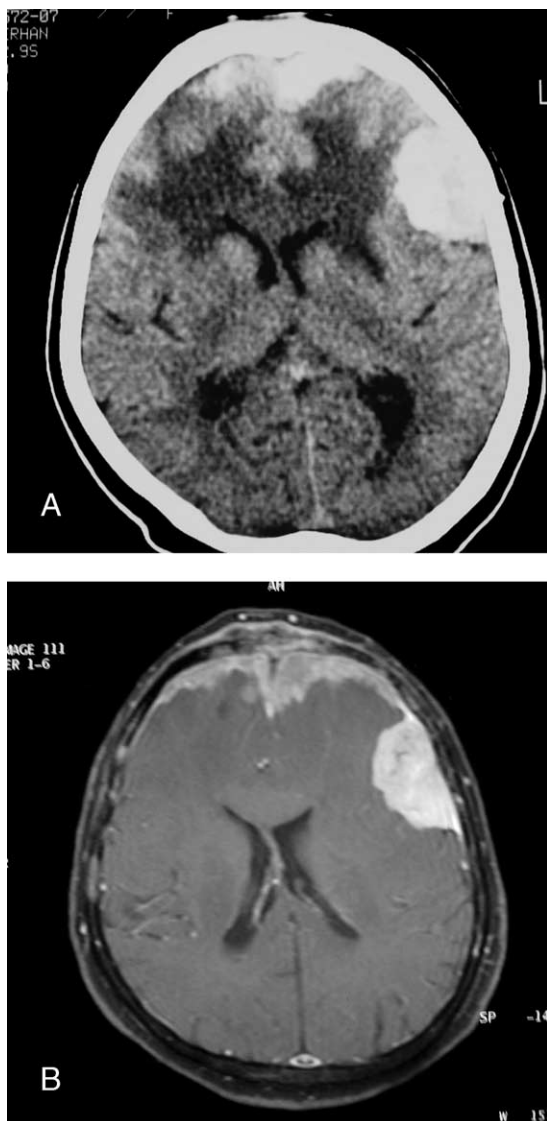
A: Contrast-enhanced CT image demonstrating bilateral frontal mass and left sylvian mass with surrounding edema. B: Contrast-enhanced T1 magnetic resonance axial image reported as en plaque frontal meningioma and left sylvian meningioma connected with dural tail.
